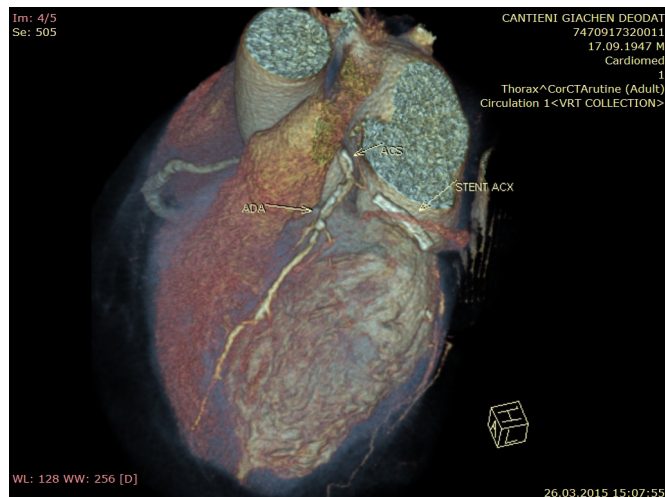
Angio CT Multislice showing occlusion of the circumflex artery
